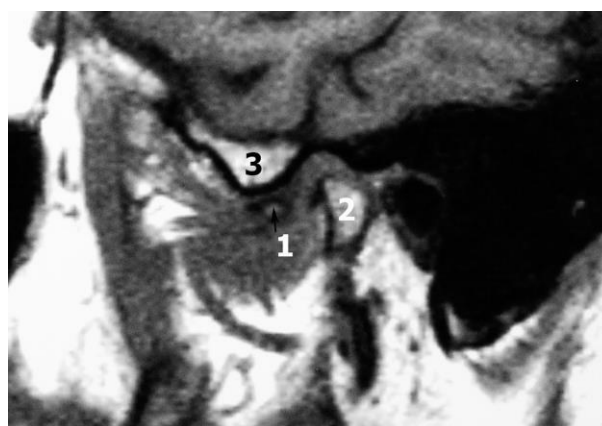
Magnetic resonance imaging of left temporomandibular joint (1 - displaced disc; 2 - condyle; 3 - tuberculum)
